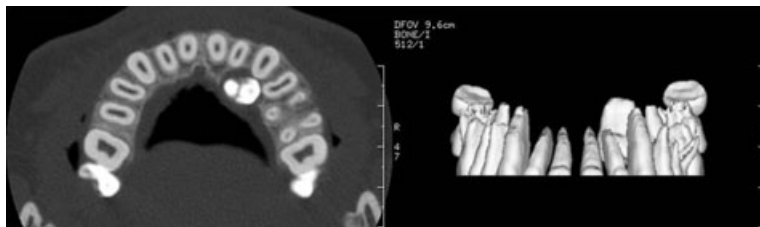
Computed tomography axial image (left) and three-dimensional reconstruction image (right). Tooth 25 was located palatal to tooth 23.
